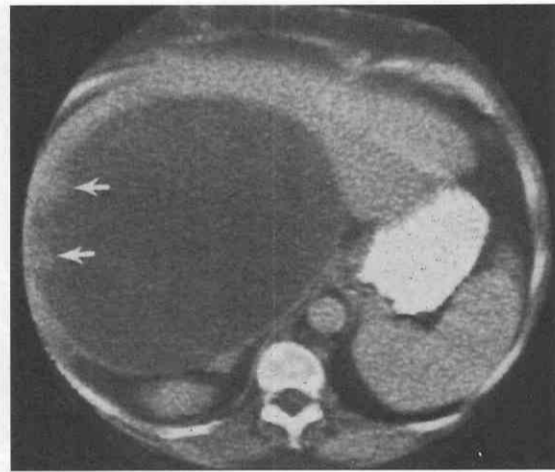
Biliary cystadenocarcinoma. Contrast-enhanced CT scan shows this large cystic mass of the liver containing mural nodules (arrows), distinguishing it from a large simple cyst.
